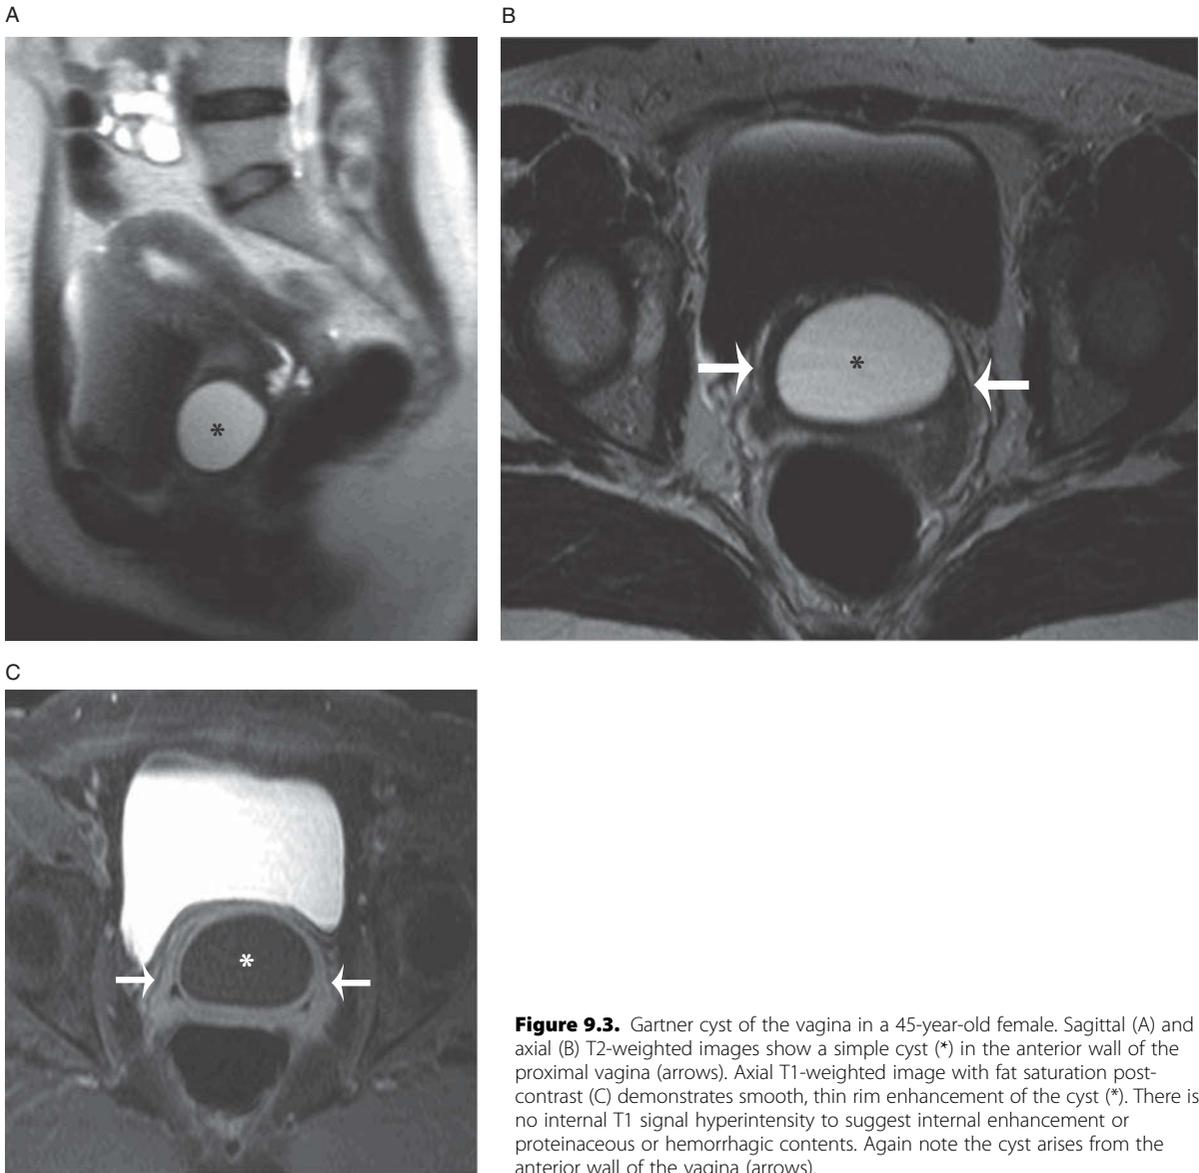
Gartner cyst of the vagina in a 45-year-old female. Sagittal (A) and axial (B) T2-weighted images show a simple cyst (*) in the anterior wall of the proximal vagina (arrows). Axial T1-weighted image with fat saturation post-contrast (C) demonstrates smooth, thin rim enhancement of the cyst (*). There is no internal T1 signal hyperintensity to suggest internal enhancement or proteinaceous or hemorrhagic contents. Again note the cyst arises from the anterior wall of the vagina (arrows).
